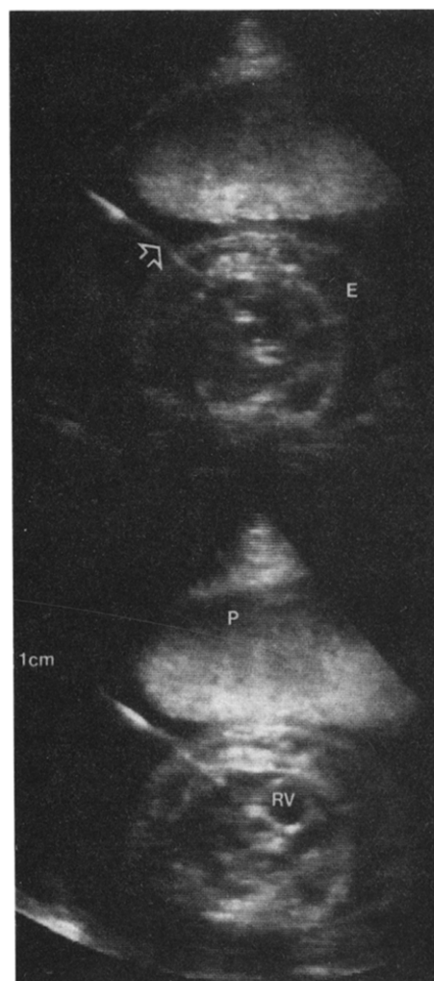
Two-dimensional fetal echocardiograms depicting the pacemaker lead passing through the chest wall and coiled in the right ventricle (RV). The arrow identifies the pacemaker cable; E = edema of chest wall; P = placenta.
